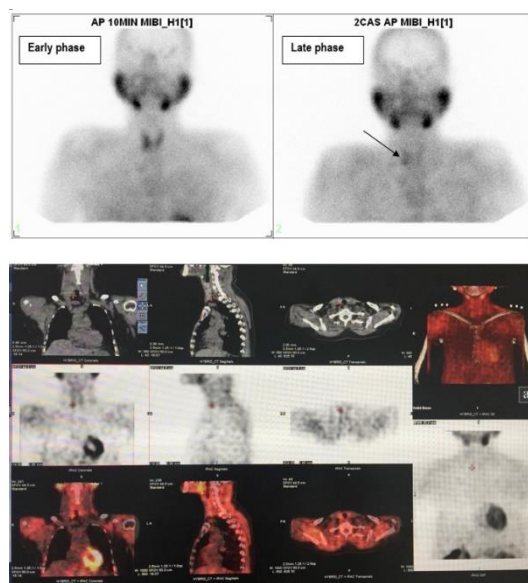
Patient with parathyroid adenoma (negative early planar, positive late planar and positive SPECT/CT images).
